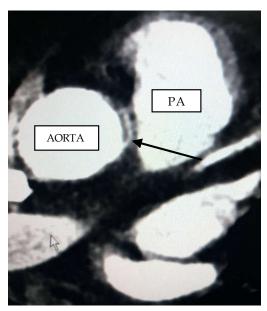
RCA between aorta and Pulmonary artery in CT angiogram
